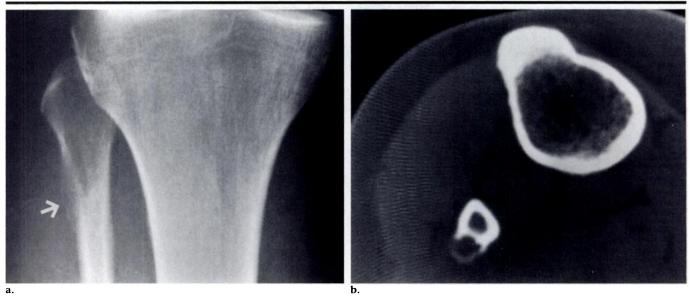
Small parosteal aneurysmal bone cyst. (a) Anteroposterior radiograph shows unilaminar periosteal new bone (arrow) along the proximal fibular shaft. (b) CT image shows that the lesion is cortically based and surrounded by a thin rim of periosteal new bone.
